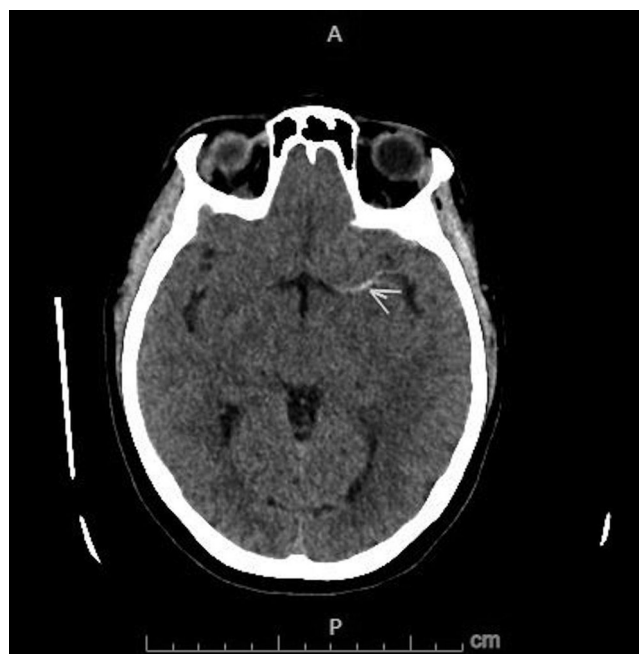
Non-contrasted axial computed tomography head imaging showing a left hyperdense middle cerebral artery sign (green arrow).
